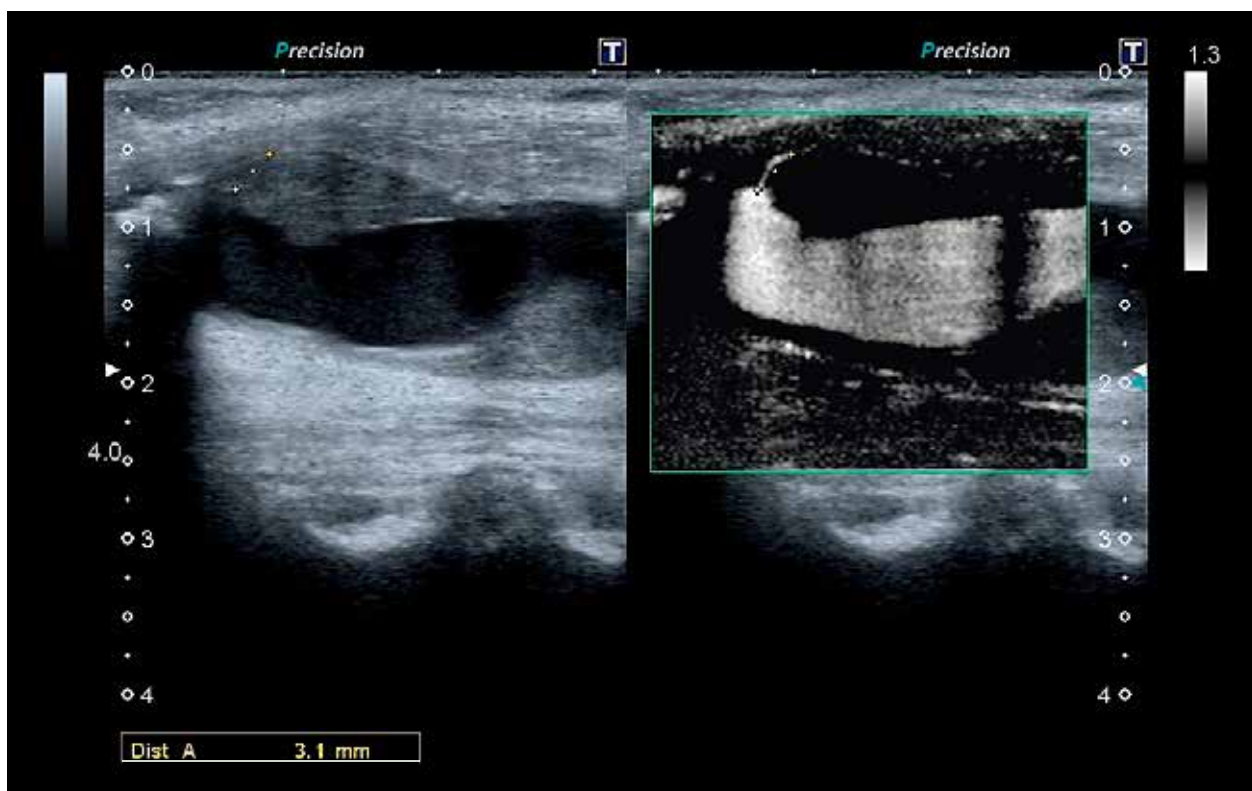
Conventional B-mode ultrasound with and without SMI in TwinView layout. More than 70% carotid stenosis, uniformly hypoechoic plaque located at right carotid artery bifurcation. Left, conventional B-mode ultrasound examination of the plaque. Right, duplicate of the B-mode as shown in the left picture subtracting the background information to focus only on vasculature with SMI and showing intraplaque neovascularization (IPN) in the plaque. Plus signs show the distance measurement of the IPN detected by SMI moving towards the plaque core, Grade 3.
